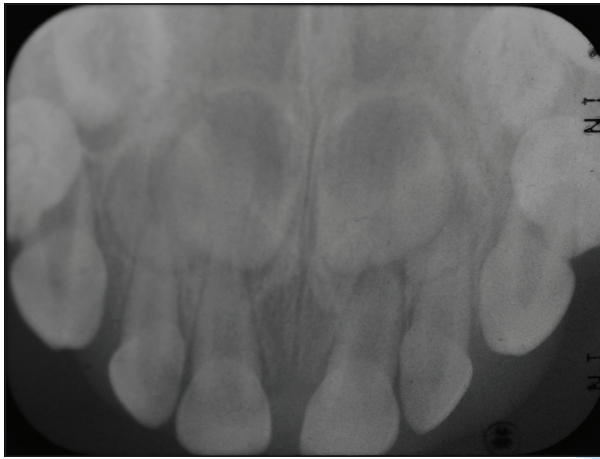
Radiographic follow-up of 14 months. Note the expected development of the permanent successors
